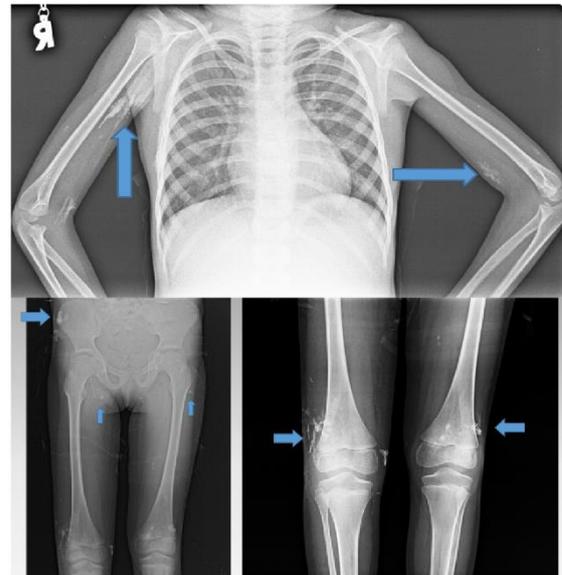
Plain radiograph chest, arms hip and knee joints showing well defined areas of linear sheet like soft tissue calcifications, which were not related to bone or periosteum.
